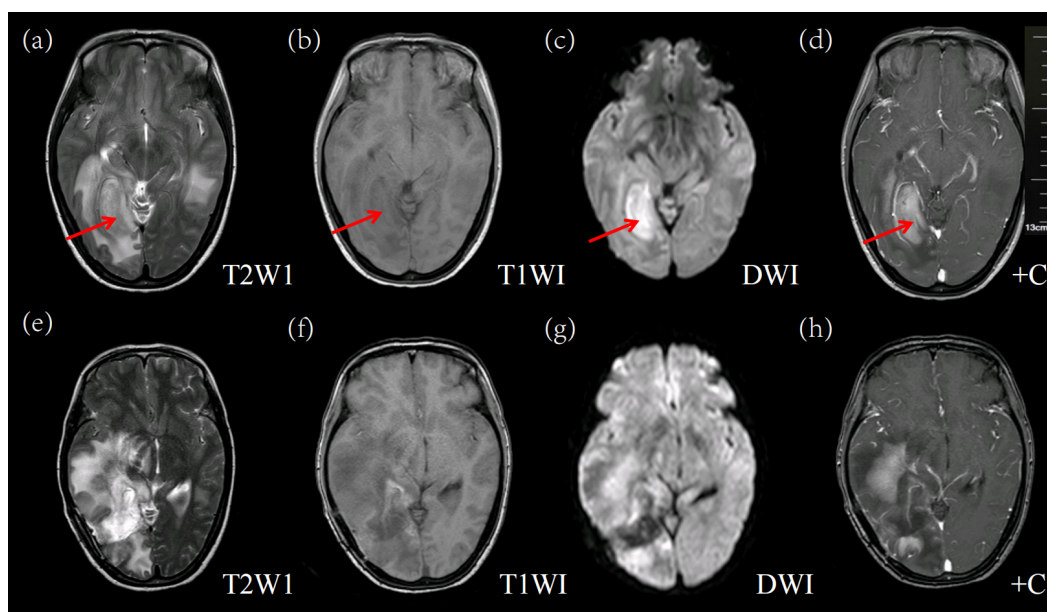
Pre-and post-treatment brain magnetic resonance imaging (MRI) scans of a patient without chemotherapy after surgery. (a–d) Pre-treatment images, show a lesion in the right occipitotemporal region. Axial T2-weighted images (T2WI) (a), axial T1-weighted images (T1WI) (b), axial diffusion-weighted imaging (DWI) (c), and enhanced scan (+C) (d) show significantly uniform enhancement. (e–h) Post-surgical images after lesion resection: mixed signal shadow in the original right occipitotemporal surgical area. Axial T2WI (e), axial T1WI (f), axial diffusion-weighted imaging (DWI) (g), and enhanced scan (+C) (h) show partial enhancement around the lesion area. Red arrows indicate areas of abnormal signal intensity, suggesting lesion regions.
